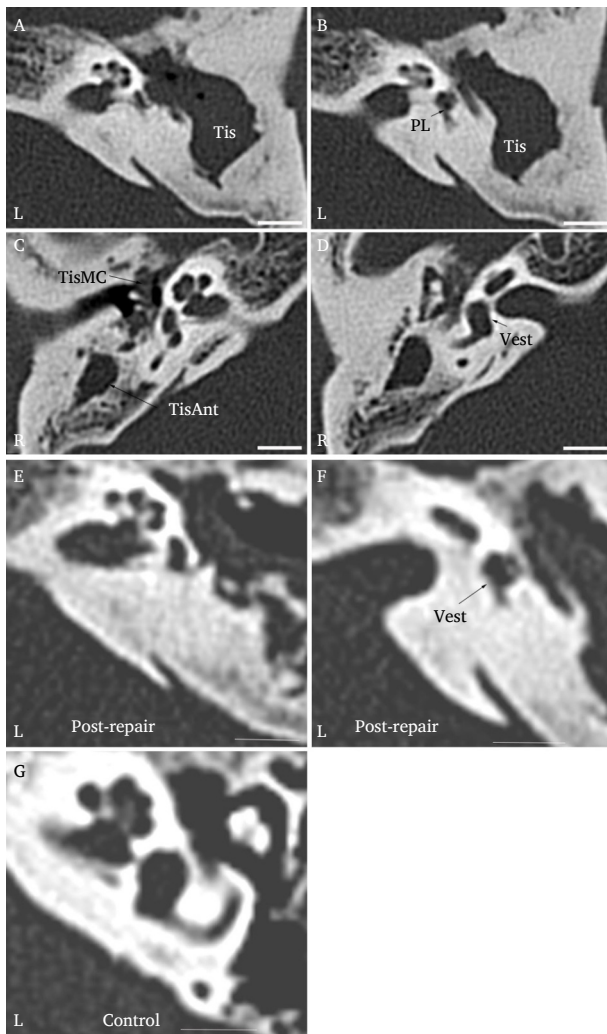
CT images of the temporal bone before surgery in the right ear in 2023. A possible pneumolabyrinth (PL) was detected in the vestibule (B) compared with the right side (D); no pathological changes were found in the cochlea (A and C). Seventy-six days postsurgery, the suspected PL disappeared in the left vestibule (F); no changes were detected in the left cochlea (E). A control image of a normal ear is shown (G). Tis: soft tissue; TisAnt: soft tissue in the antrum; TisMC: soft tissue in the middle ear cavity. Scale bar = 6.0 mm.
